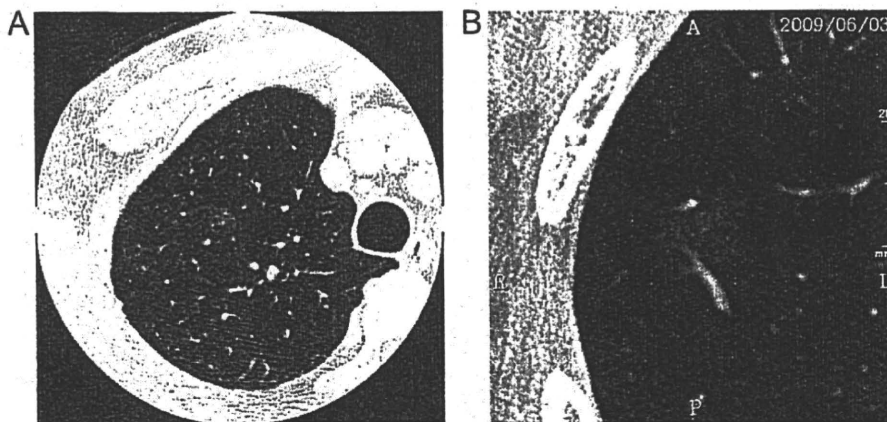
High-resolution CT image of pure GGN. (A) Atypical adenomatous hyperplasia and (B) adenocarcinoma.
